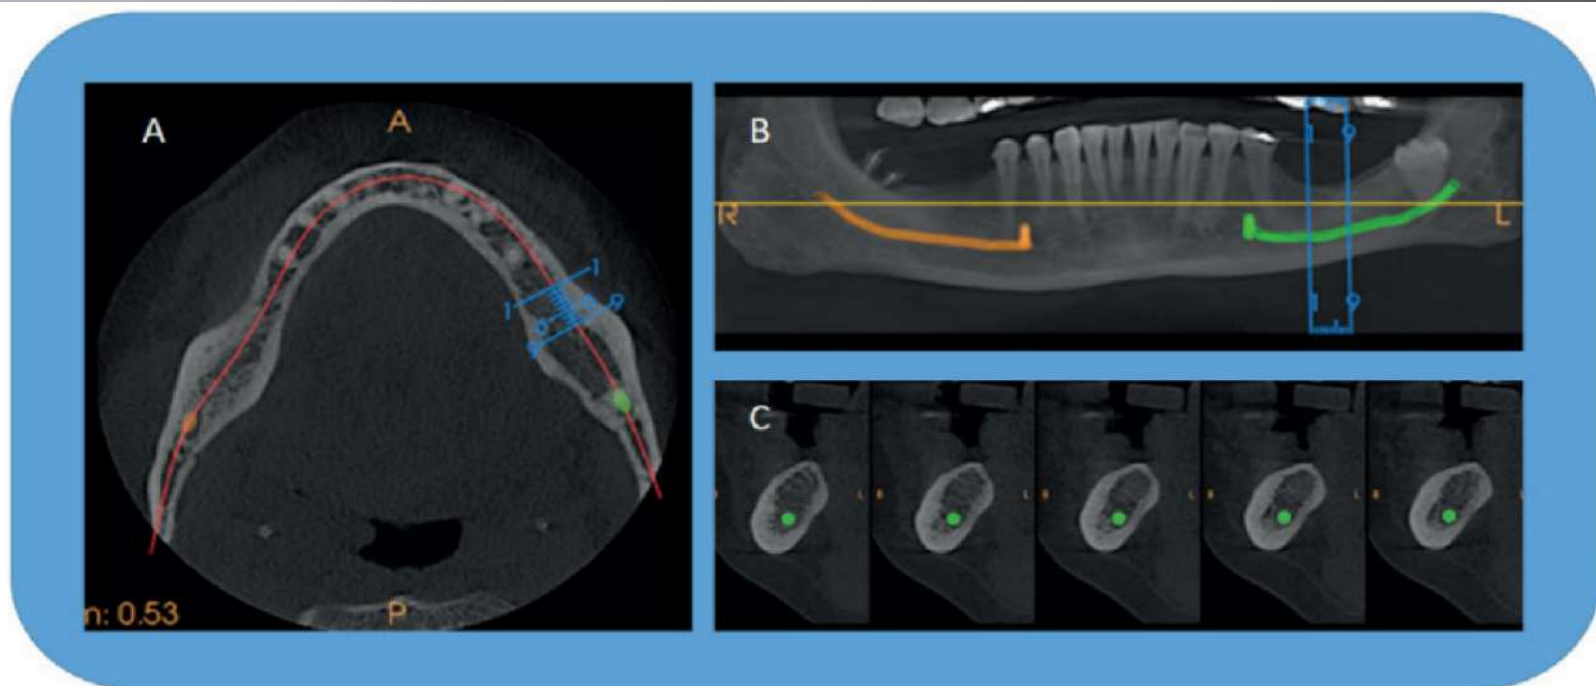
CBCT scan– MPR showing axial view (A) with curved line (red solid line) for “panoramic” view (B) and set of cross-sections, 1-mm-thick images (C) of a potential implant site in the lower left mandible. Blue lines on the axial and panoramic images indicate the location of the cross-sections. Apart from information of bone quality and dimensions, the cross-sections reveal the amount of lingual undercut and location of the inferior alveolar canal (green).
